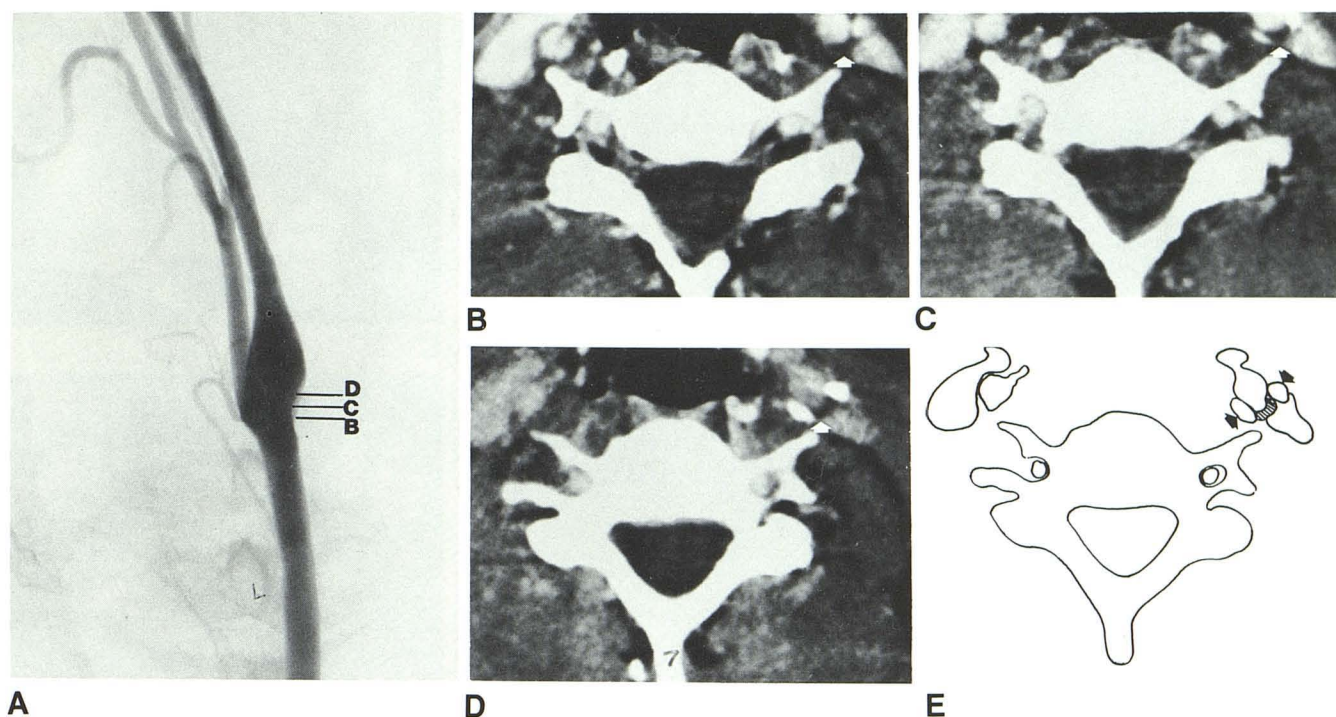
Case 3, 45-year-old man with left brain TIAs. A, Angiogram. Intimal defect (1+) on posterior wall of internal carotid artery at bifurcation. CT (B–D) shows 2+ change (CT plaque appears larger than on angiogram) on posterior wall of internal carotid at bifurcation (arrows). Two calcium deposits lie within
